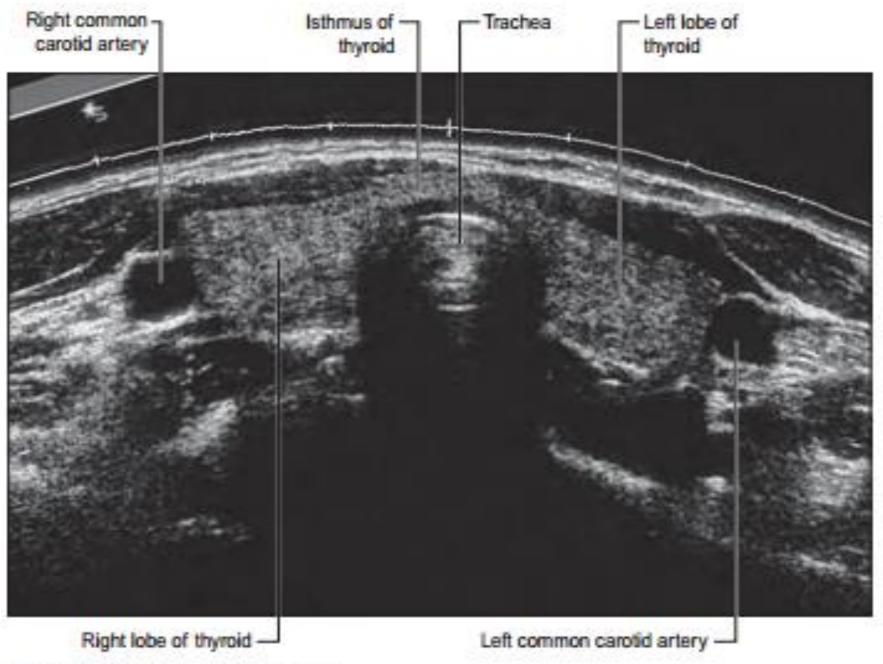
Thyroid sonogram.
